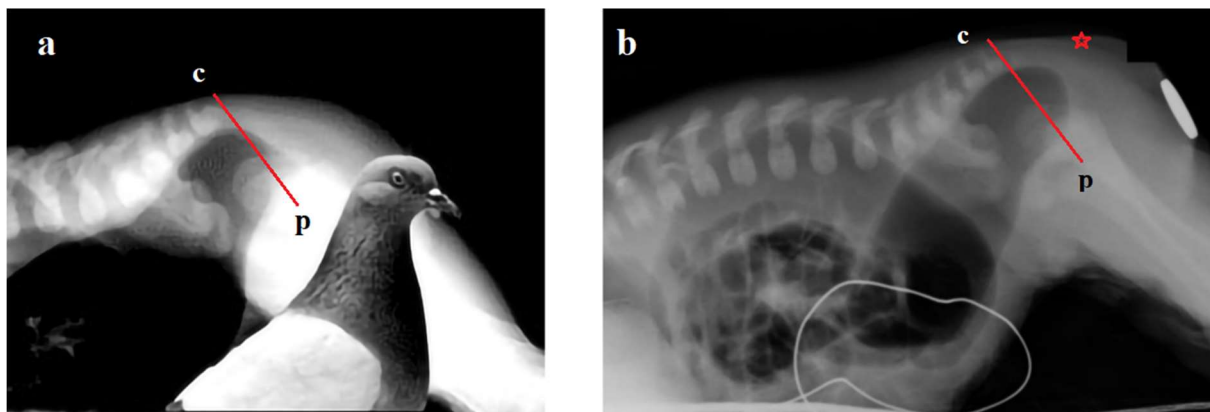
(a-b) Caption from the article: “Pigeon sign” is highlighted. (a) Presence of the “pigeon sign”. (b) No “pigeon sign”. I have drawn a red line “I”. It is known that relaxation of the IAS occurs about 18 times per minute. During this time, fecal retention is achieved by contraction of the external anal sphincter (EAS) and the puborectalis muscle (PRM), which pulls the posterior wall of the anal canal forward. This radiographic picture is a manifestation of the anorectal inhibitory reflex [6,7]. (b) This radiograph was taken at one of the moments of the anal canal opening.
